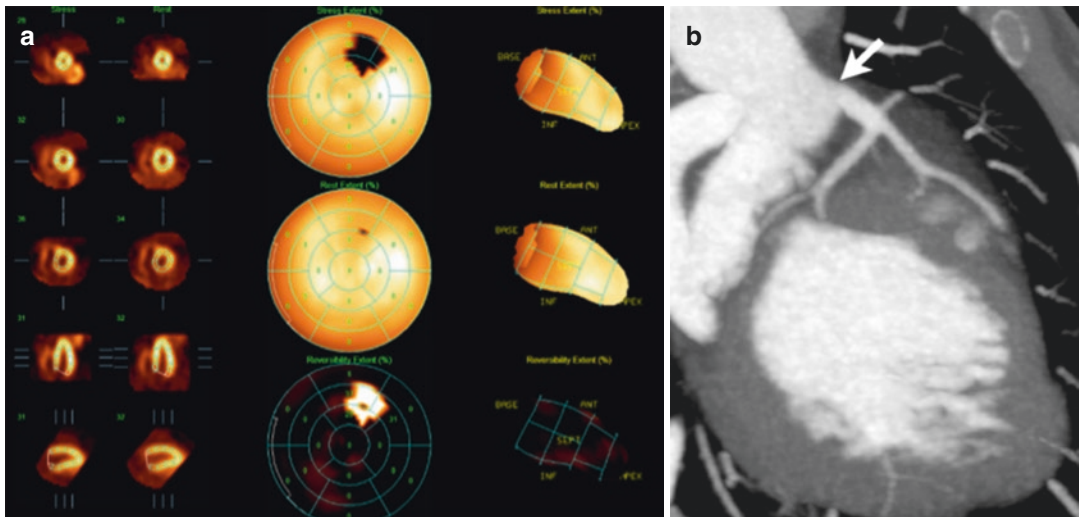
False positive SPECT MIBI study in a patient following the arterial switch procedure. (a) Bullseye plot from stress-rest MIBI demonstrates an area of apparent reversible ischaemia in the basal to mid-anterior wall. (b)
